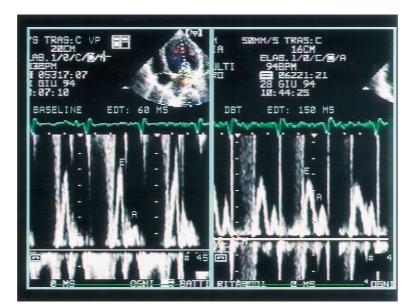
Example of disappearance of restrictive left-ventricular filling pattern during DET. At baseline Doppler study (left frame) the transmitral curve showed an increased E/A ratio (3.3) and an extremely shortened E deceleration time (60 ms). During DET (right frame), the E/A ratio decreased (1.75) and E deceleration time increased (150 ms).
